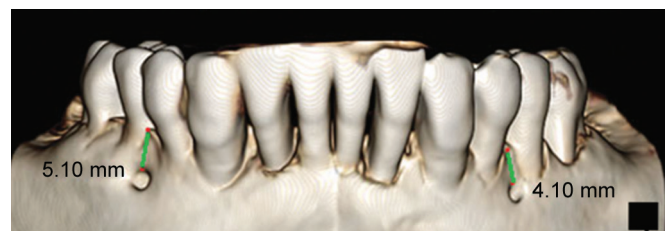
CBCT 3D reconstruction image showing the distance between the upper border of MF and the alveolar crest
